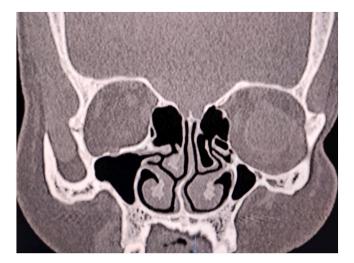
Coronal CT scan showing concha bullosa on the left middle turbinate and a right DNS.
